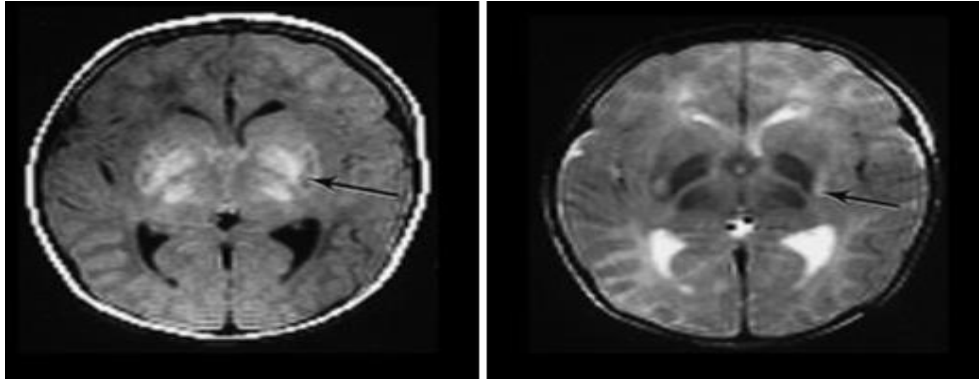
Sample MRI image of Neonatal Asphyxia
